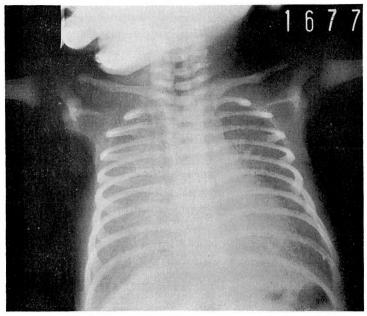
Chest roentgenogram taken when the patient was eight days old. It shows a normal-sized heart and reticular markings in the lung fields.
